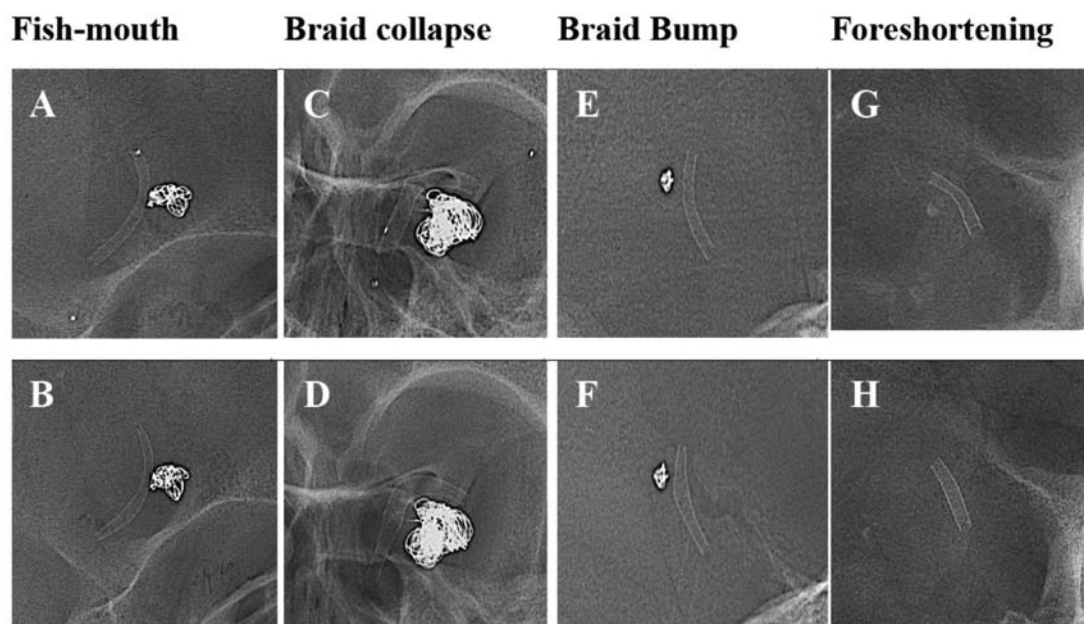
Examples of braid deformation types: unsubtracted radiographs at the end of the treatment (upper row) and at follow-up (lower row) showing: fish-mouthing (A,B), braid collapse (C,D), braid bump (E,F) and foreshortening (G,H).
